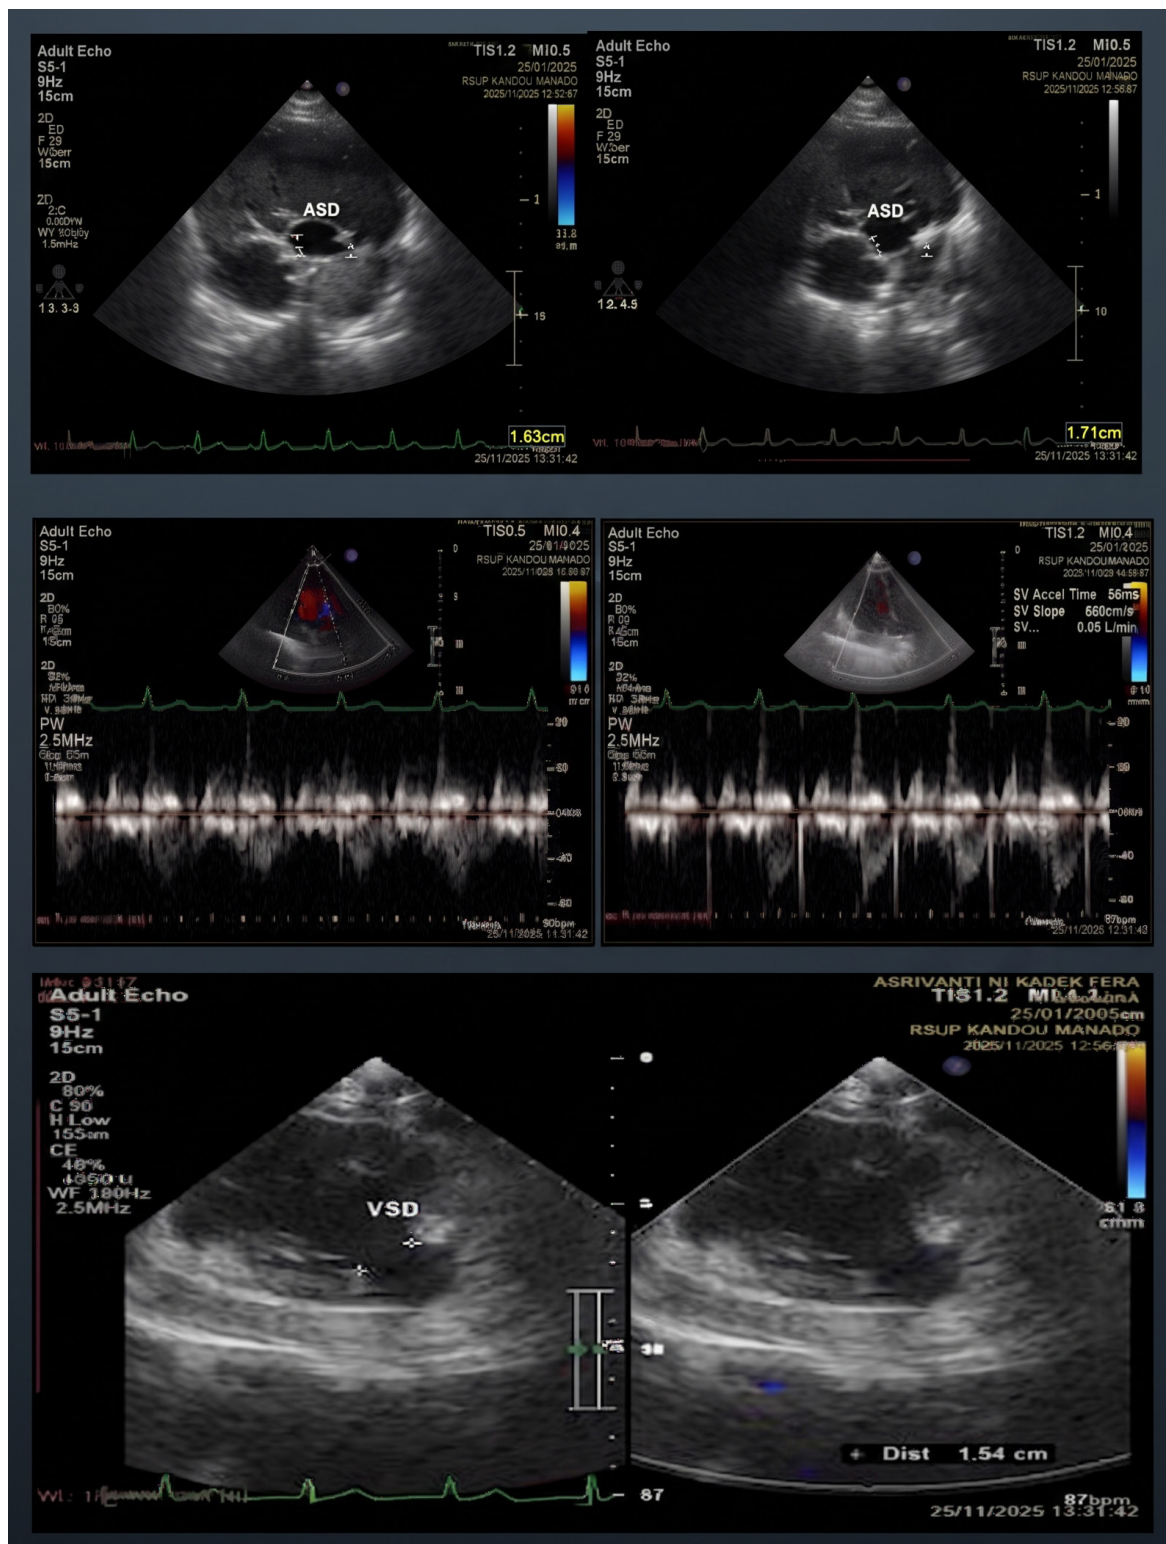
Transthoracic echocardiography
